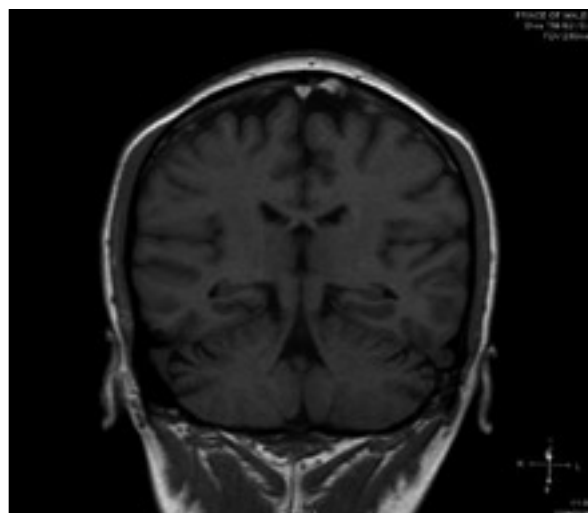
Magnetic resonance imaging (T1-weighted) showing hyperintensity in the superior sagittal sinus, signifying the subacute blood clot
